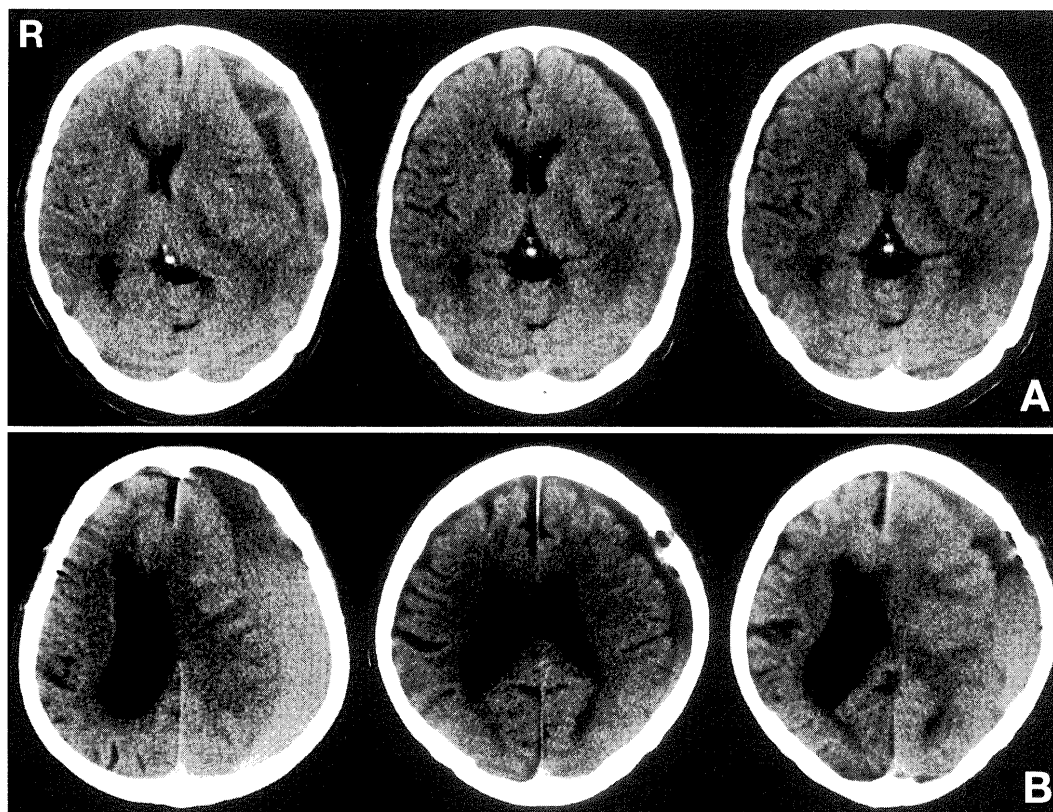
Serial computed tomography scans of patients with chronic subdural hematoma. A: Chronic subdural hematoma disappeared after surgery in a patient treated with etizolam (left to right: preoperative, 1 month postoperative, and 2 months postoperative). B: Chronic subdural hematoma recurred 3 weeks after surgery in a control patient (left to right: preoperative, 2 weeks postoperative, and 3 weeks postoperative).
